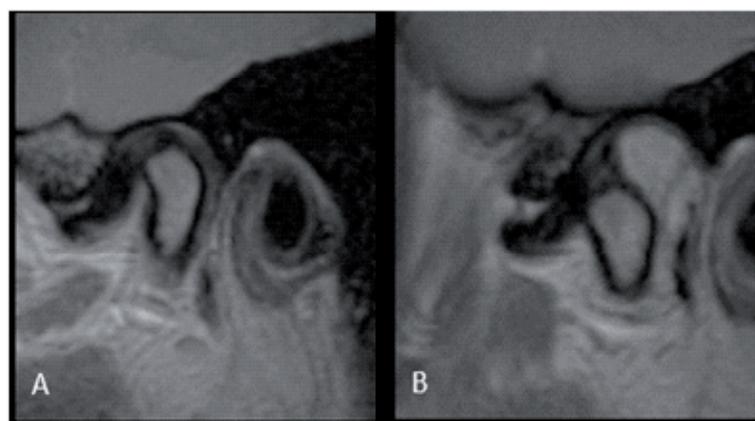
Sagittal images on MRI Fig. 2: Sagittal images on MRI showing TMJ disc displacement without reduction (DDNR): A) closed mouth; B) open mouth
